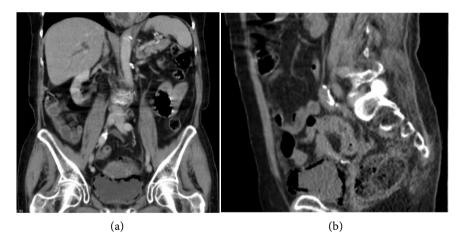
Coronal, sagittal and axial views of plain CT scan of the abdomen showing a diffuse collection of gas in the bladder wall.
